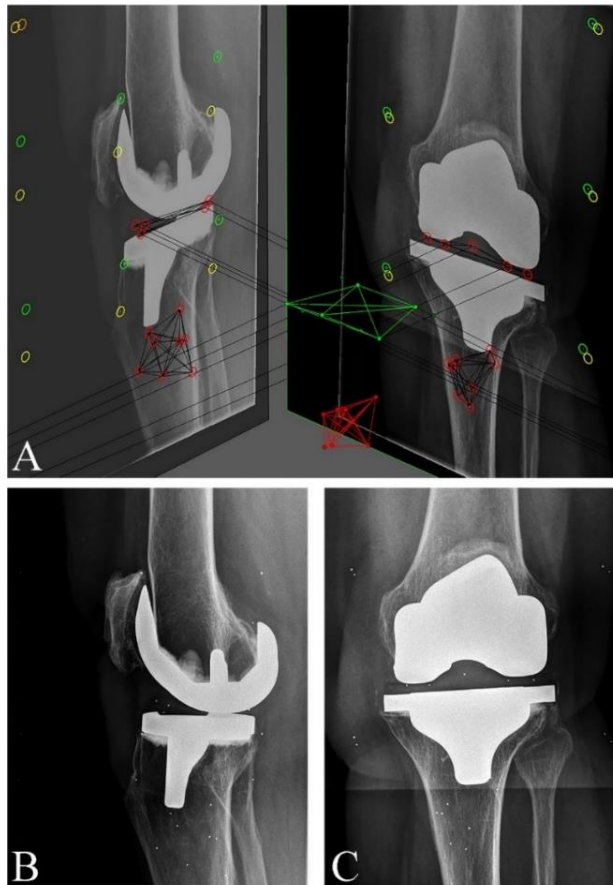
RSA images of a cemented TKA implant. Figure 4-A. Biplanar (lateral and anteroposterior) views with markers inserted in the polyethylene insert and tibial bone. Figure 4-B. Lateral radiograph of the same implant, which was classified as continuously migrating. Figure 4-C. Anteroposterior radiograph of the same implant.
